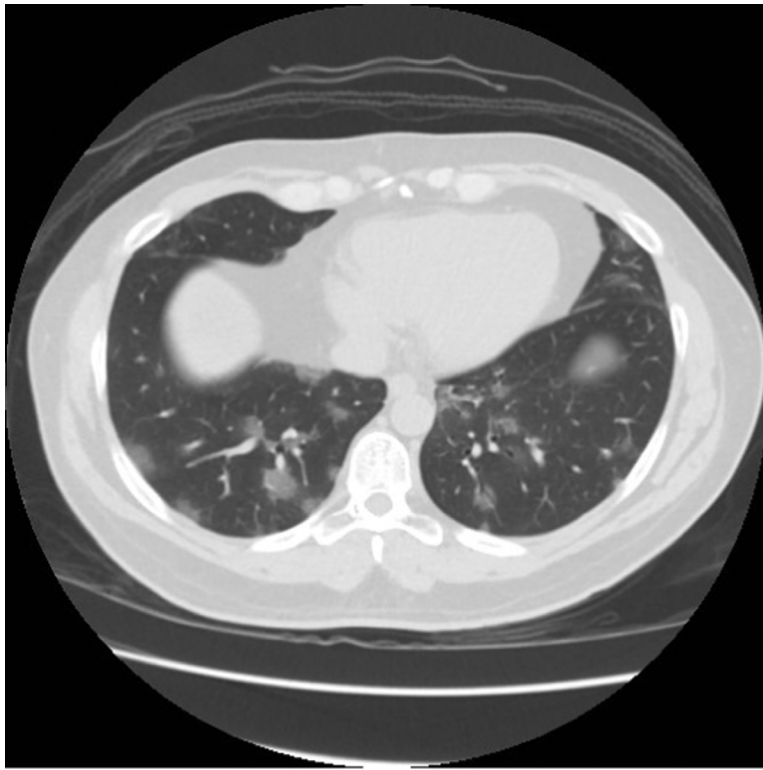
A case of MERS-CoV; Axial CT image in pulmonary window second day after presentation showing bilateral ill defined ground glass opacities.
